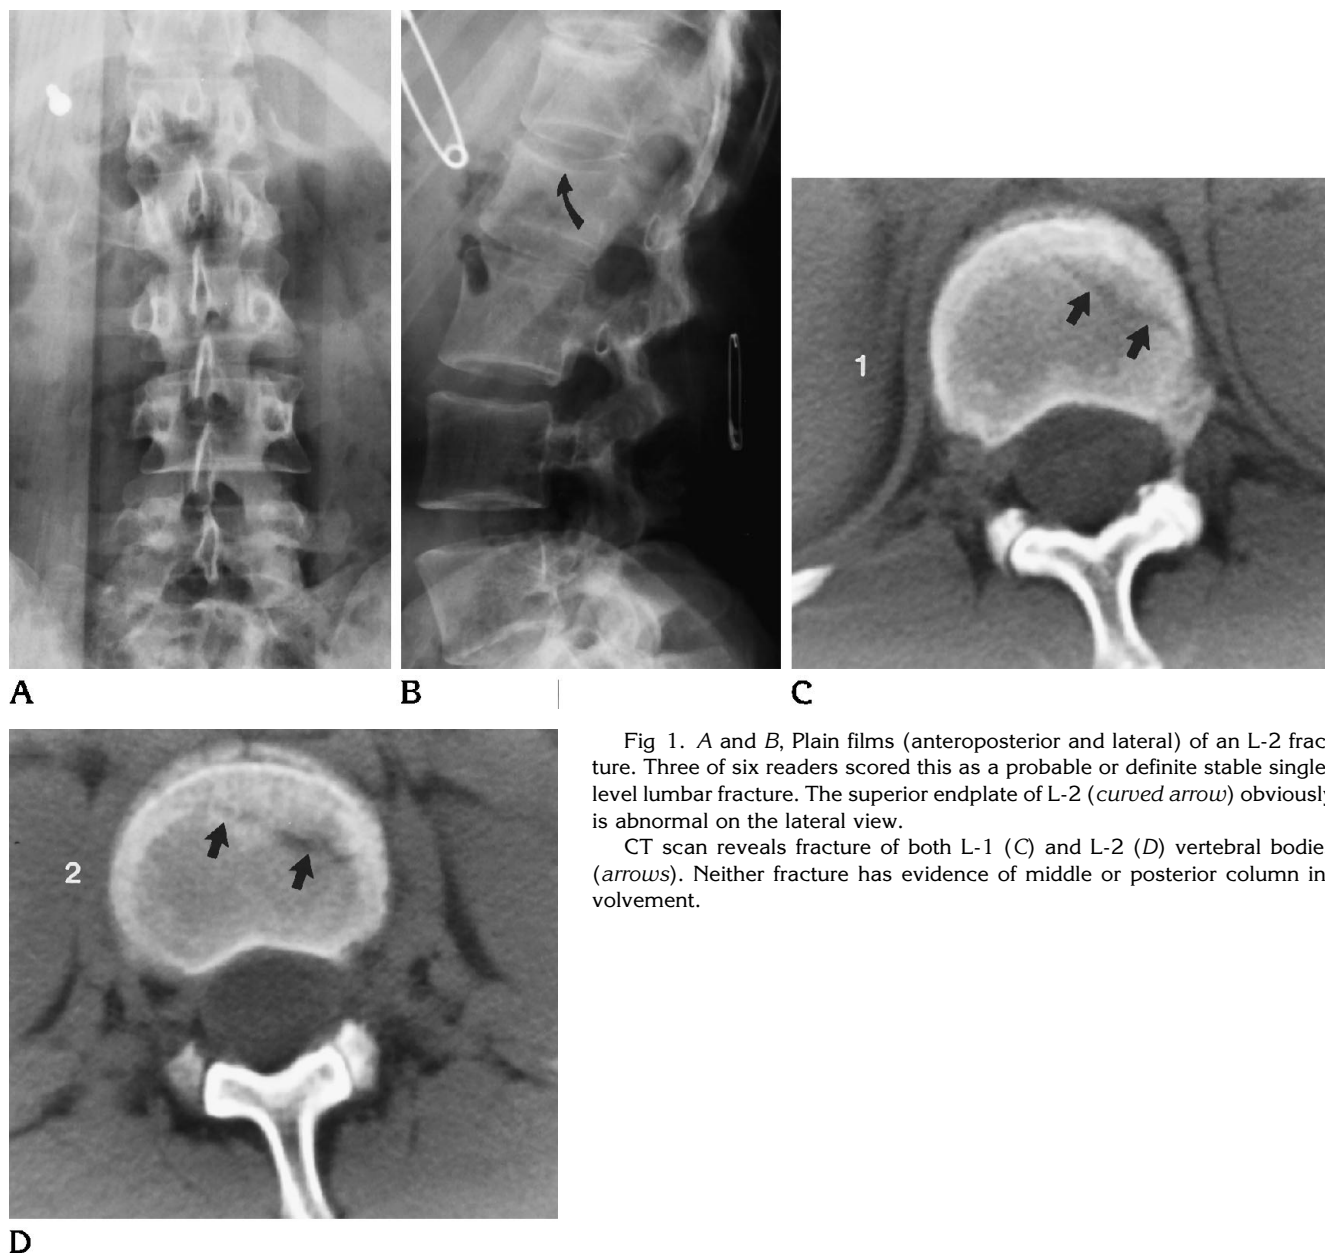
A and B, Plain films (anteroposterior and lateral) of an L-2 fracture. Three of six readers scored this as a probable or definite stable single-level lumbar fracture. The superior endplate of L-2 (*curved arrow*) obviously is abnormal on the lateral view.
